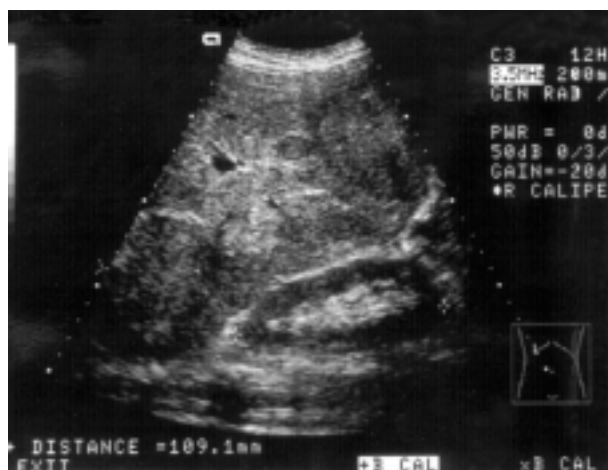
Abdominal ultrasound showing multiple liver masses.
